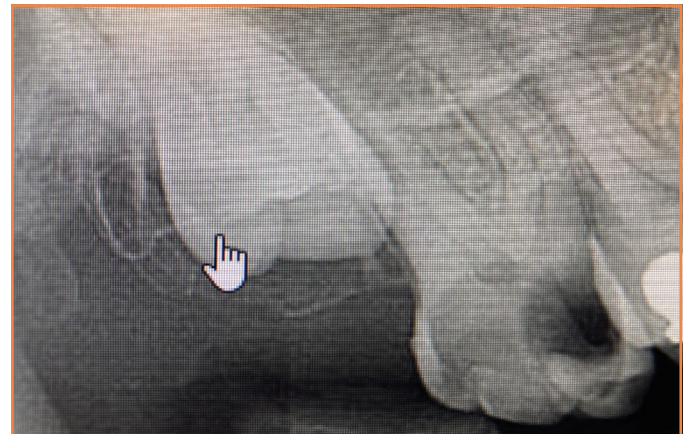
Preoperative radiograph showing a grossly carious 17 adjacent to an unerupted 18. The antral floor appears to lie about halfway down the roots of the 17
